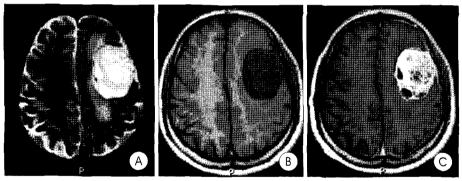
Magnetic resonance(MR) image showing a mass on the left frontal area, which is 4×5 cm in size. Small multiple cysts are noted and dural tail sign is not prominent. It is mixed-signal on 12-weighted MR image(A), low signal intensity on 11-weighted MR image(B), inhomogeneously enhancing on 11-weighted gadolinium-enhanced MR image(C).
